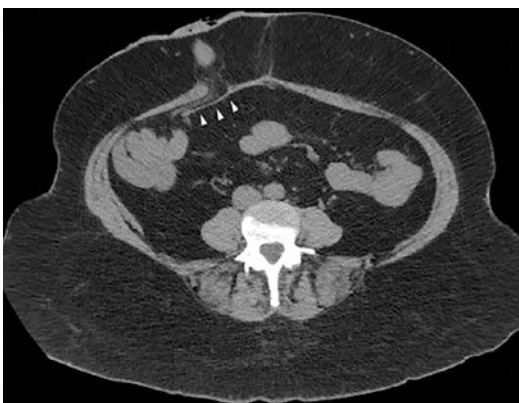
Axial CT imaging of a successful laparoscopic IPUM Sugarbaker repair of an end ileostomy parastomal hernia. The lateralized bowel can be seen entering a tunnel of mesh (arrowheads) before traversing the rectus abdominis muscle and heading towards the mucocutaneous junction
